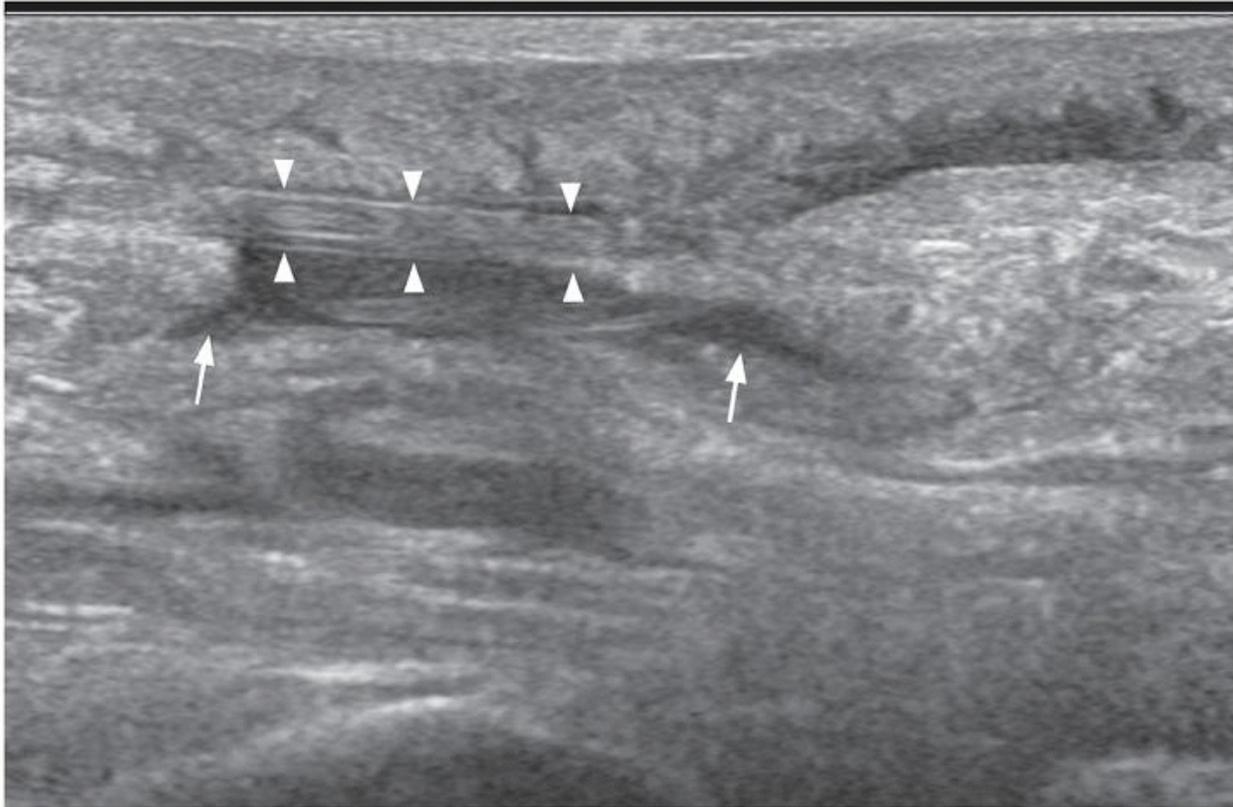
Longitudinal ultrasound of complete Achilles tendon tear, medial edge. The retracted ends of the tendon are shown (arrows) with the tendon gap filled with fluid. There is also an intact slightly swollen plantaris tendon (arrowheads) traversing the tendon gap. Do not confuse this with intact Achilles tendon fibers.
